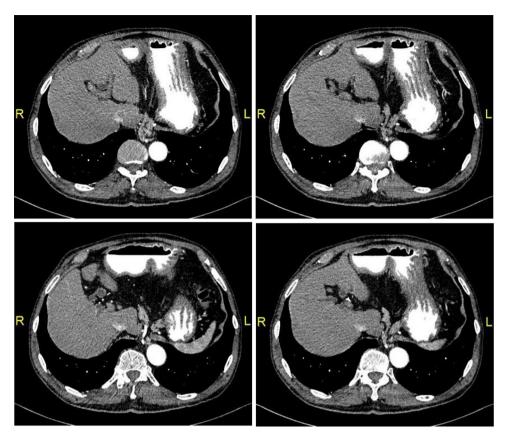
Axial computed tomography images of the abdomen in the arterial phase with oral and intravenous contrast media. The pancreatic body is located above the diaphragma in the mediastinum.
